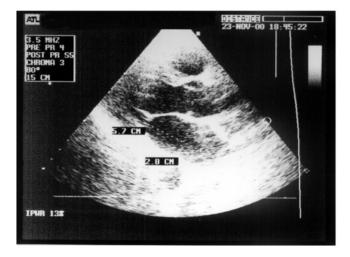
Parasternal long-axis view and left atrial dimensions 2 months after surgical correction of the arteriovenous fistula.
